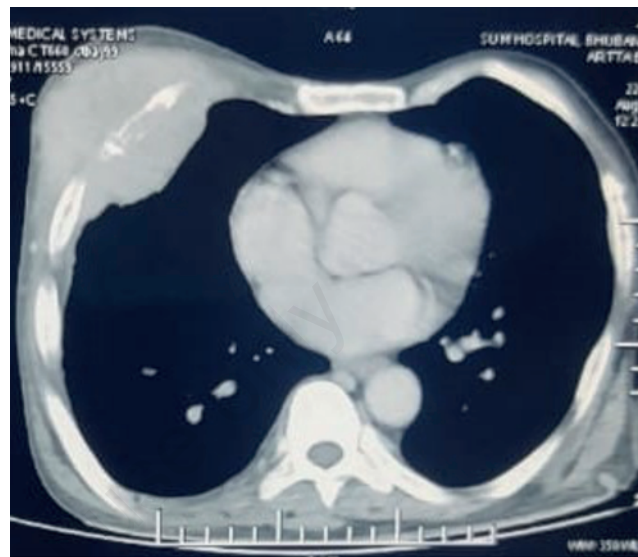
Contrast-enhanced computed tomography of the thorax (axial image) showing a homogeneously enhancing soft tissue density lesion measuring 8.7×6.1 cm in the right anterior chest wall along with pathological fracture in the anterior aspect of the fifth rib.
